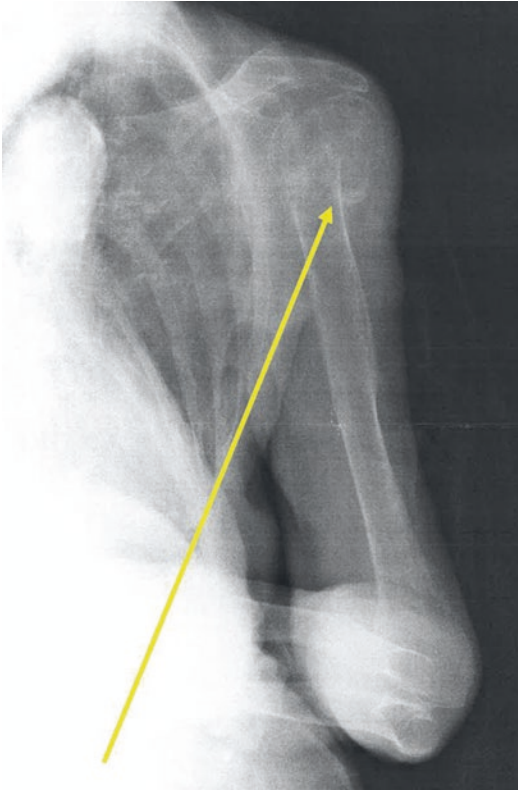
Fracture of left humeral head (anteroposterior radiography of left arm): no history of fall
